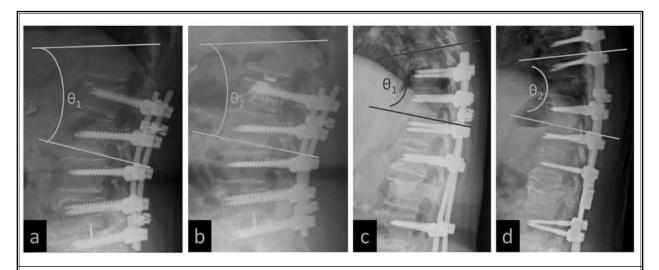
The Cobb angle was measured as the angle between the superior endplate of the superior vertebra and the inferior endplate of the vertebra inferior to the fractured vertebra on lateral plain films. (a, c) Preoperative kyphotic angle ( $\theta$ 1). (b, d) Postoperative kyphotic angle ( $\theta$ 2). The kyphotic angle was calculated using the following equation: postoperative kyphotic angle – preoperative kyphotic angle, ( $\theta$ 2 –  $\theta$ 1).
